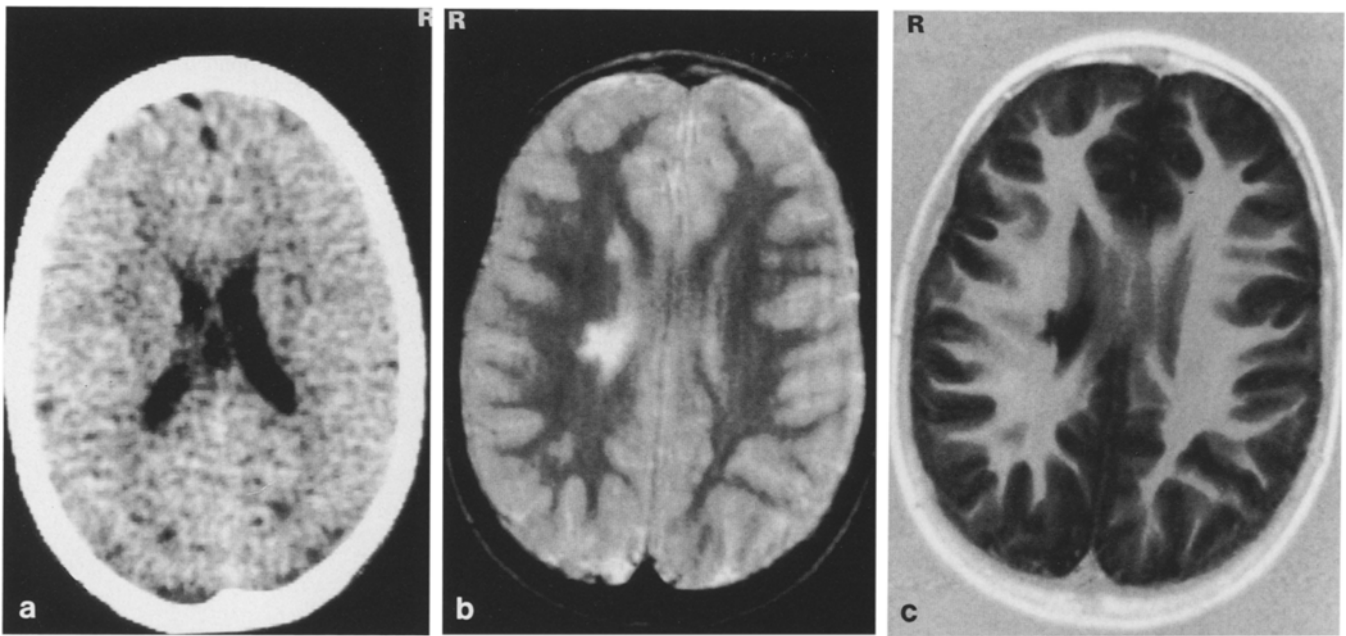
Patient 3. a Normal CT scan. Comparison with b (SE T2-weighted image) and c (IR T1-weighted image). There are right periventricular lesions
